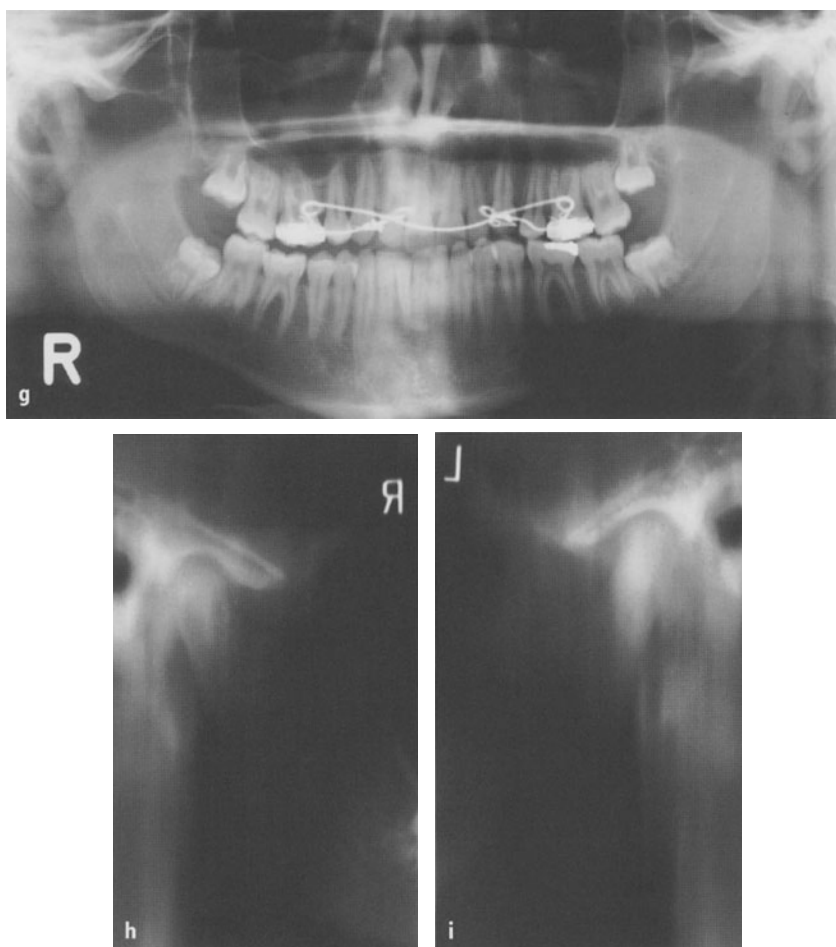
Unilateral H.E., slender-non-slender type, still active. g The panoramic view shows a picture rather typical of a H.E. non-slender type, of the left hemimandible. h, i The TMJ-ramus radiographs disclose the difference in the articular processes and ascending rami more clearly than the panoramic view
